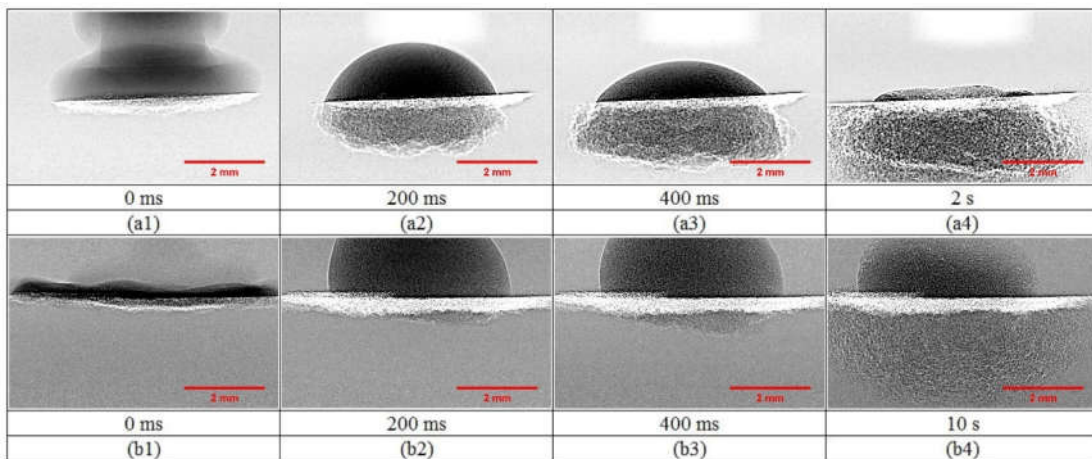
Time sequence X-ray images of the dynamic wetting and nucleation process of LMH powder with a water droplet volume of 15 μl and release heights of (a1-a4) 2.5 cm and (b1-b4) 15 cm.
